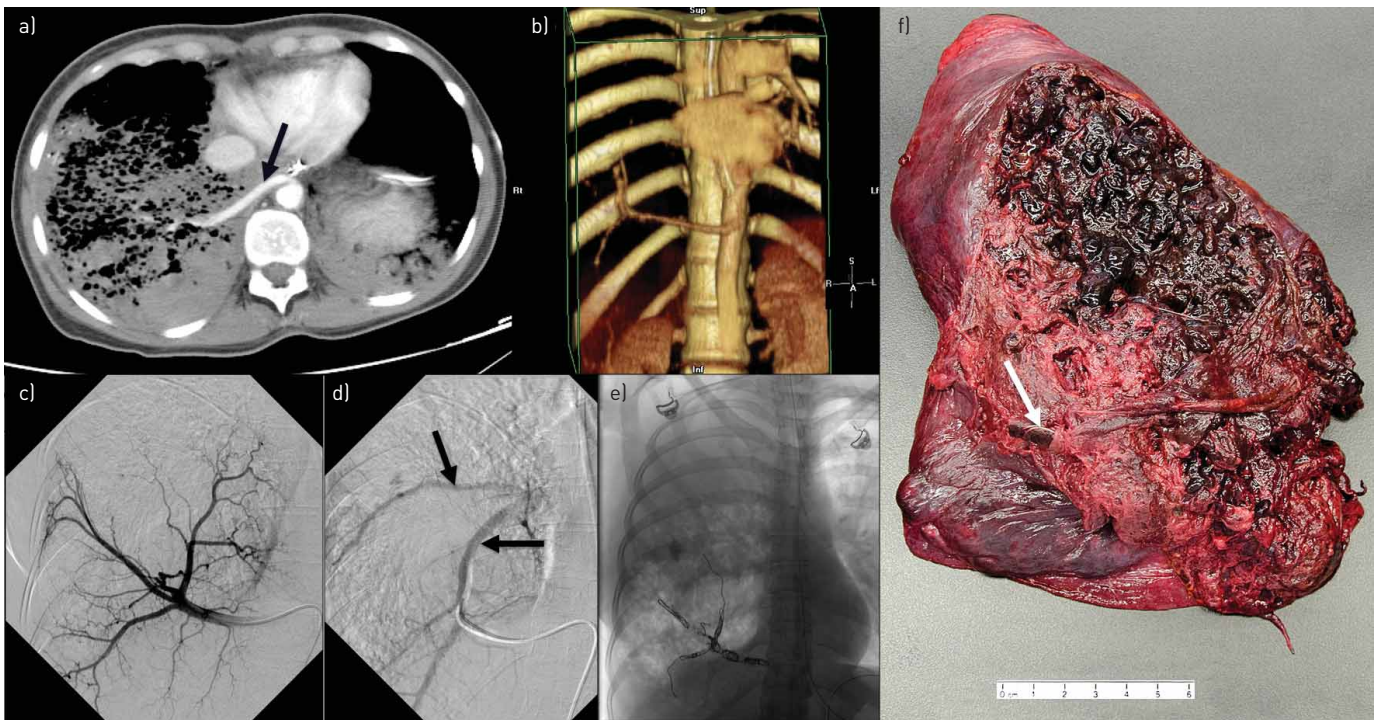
a) Multidetector computed tomographic angiography with b) three-dimensional reconstruction showing the aberrant systemic artery (arrow in a) arising from the supra-diaphragmatic aorta. The aberrant systemic artery originating from the aorta was c) visualised on aortography with d) drainage into the pulmonary veins (arrows). e) The anomalous vessel was selectively catheterised and embolised. f) Pathological examination revealed large sequestration with massive haemorrhage supplied by a thrombosed 6-mm wide feeding artery (arrow) with no evidence for malignancy or cystic adenomatoid malformation. Scale bar = 6 cm.
